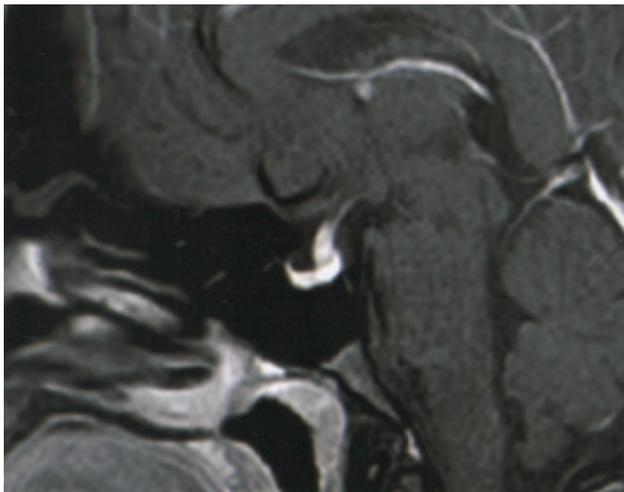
Contrast-enhanced magnetic resonance T1-weighted image, sagittal section shows contrast enhancement of thickened infundibulum.
